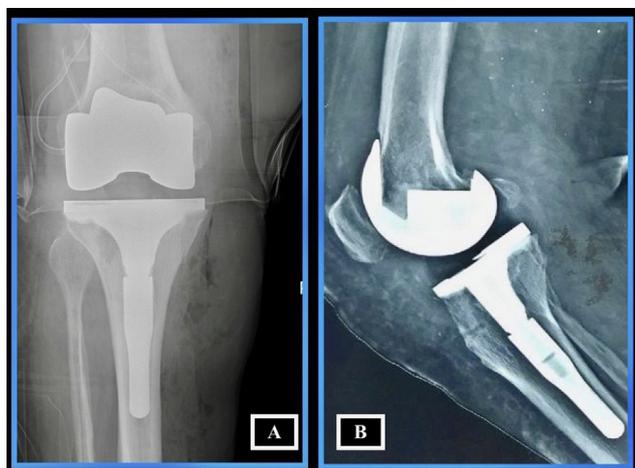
Immediate postoperative Anteroposterior (A) and Lateral radiograph (B) of a 72 year old female who developed intraoperative Medial Tibial plateau type fracture intraoperatively, which was managed by Tibial stem insertion.
